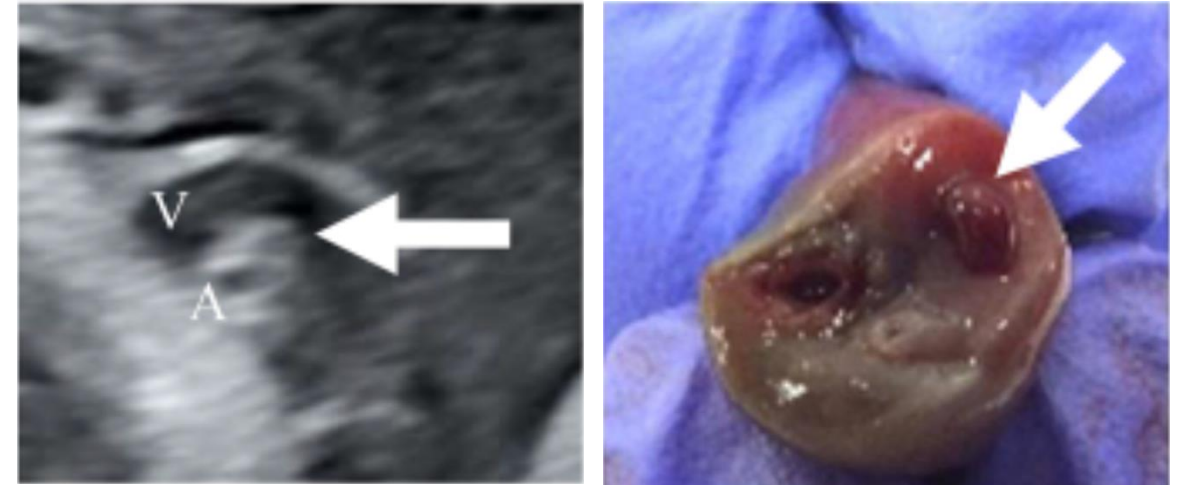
Representative end-on ultrasound image and umbilical cord cross-section of umbilical artery thrombosis (adapted from Abe et al., 2024; CC BY 4.0).
